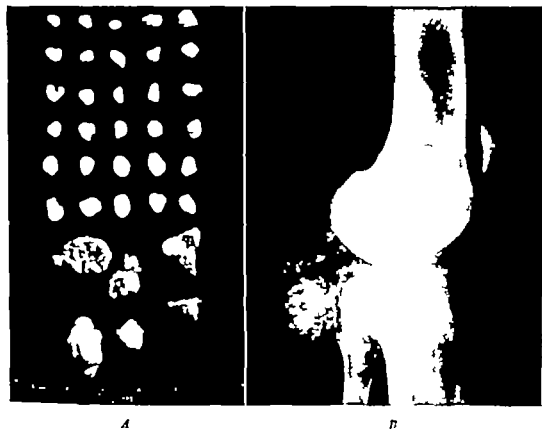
A* Photograph of numerous chondral and osteochondral joint bodies removed from an elbow in a case of osteochondromatosis. *B* Roentgenogram of a lesion of osteochondromatosis of a popliteal bursa. Pictures such as this are sometimes misinterpreted as indicating the presence of chondrosarcoma. (From Lichtenstein L., Tumors of Synovial Joints, Bursae and Tendon Sheaths, *Cancer* 8: 816-10)
